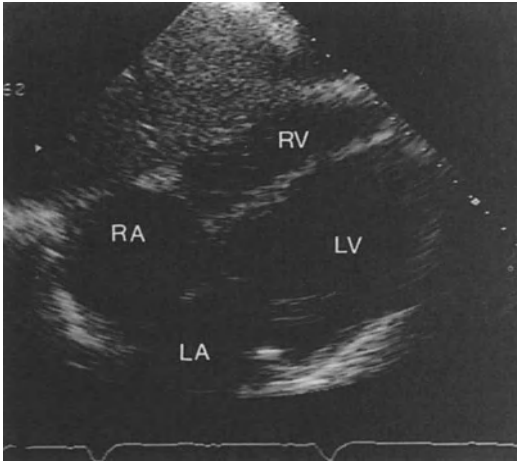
2D Echocardiogram: Subcostal four chamber view.
